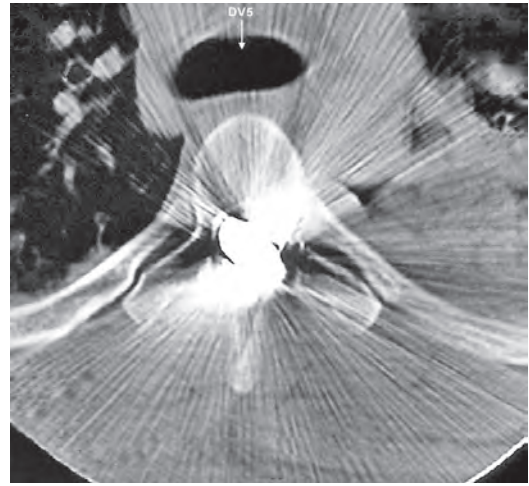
CT showing intraspinal lodgement of bullet
